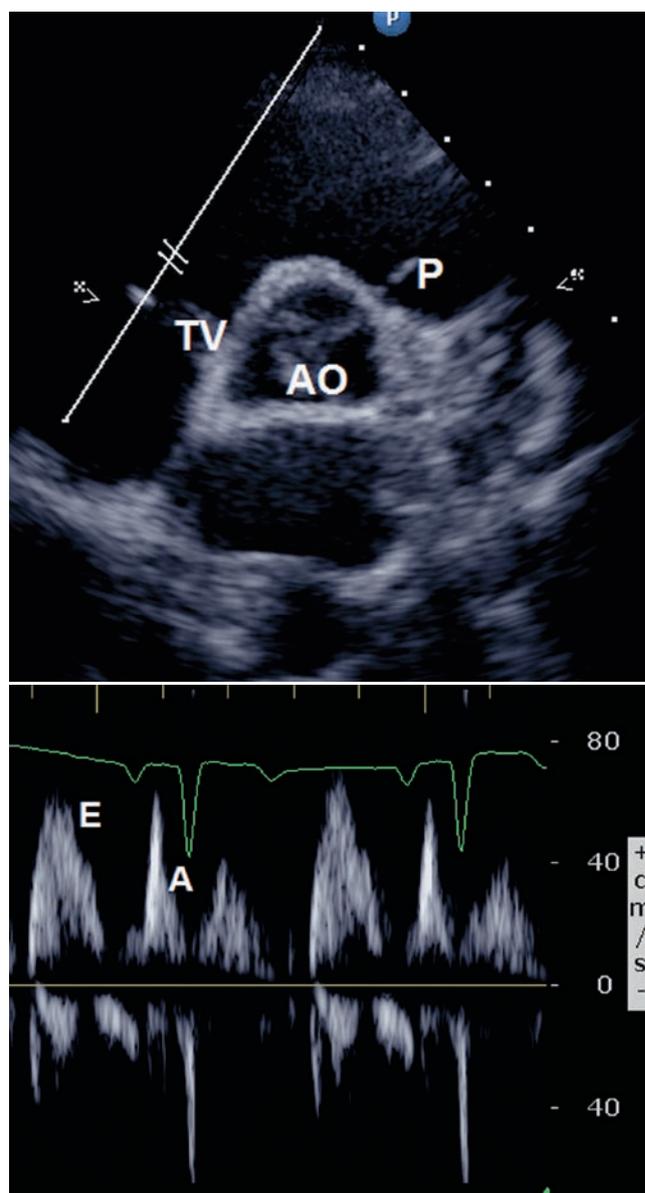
Flow velocities across the tricuspid valve are best detected using apical 4-chamber view or paraesternal short axis. Flow velocity is recorded above 0 baseline with an early and much smaller late diastolic component. In some cases, a third signal also directed towards the transducer appears during mesosystole and is probably produced by displacement of the tricuspid plane towards the apex of the right ventricle. AO aortic valve; TV tricuspid valve; P pulmonary valve
